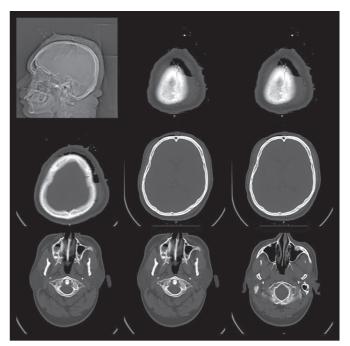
CT scan showing the extent of surgical emphysema from frontal area of the skull to the level of maxilla
